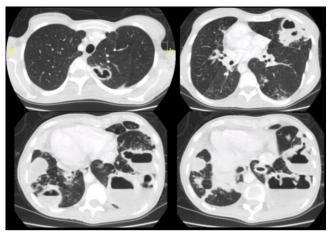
Thorax CT revealing thick-walled cavitary lesions with air-fluid levels, widespread in the upper-middle-lower zones of both lungs, bronchiectasis and mucus plugs
